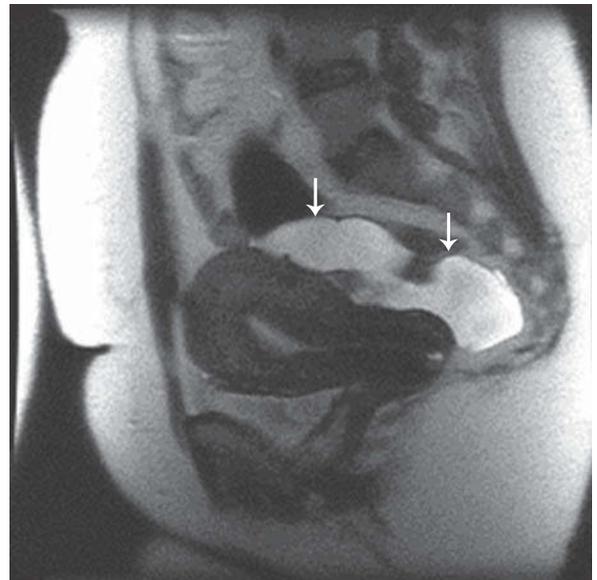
Simple hydrosalpinx in a 42-year-old female. Axial T2-weighted image (A) reveals an incomplete fold (arrow) characteristic of hydrosalpinx and the corresponding sagittal T2-weighted image (B) demonstrates the tubular configuration of hydrosalpinx (arrows).
